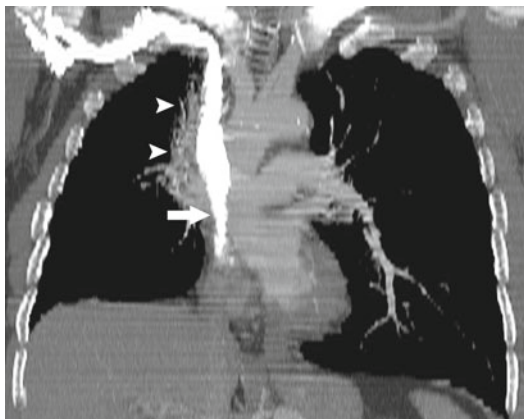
Superior vena cava stenosis following radiation therapy for lung carcinoma. Coronal reconstruction from contrast-enhanced CT scan shows stenosis of the lower superior vena cava (*arrow*) and radiation fibrosis in the medial right upper lung (*arrowheads*)
